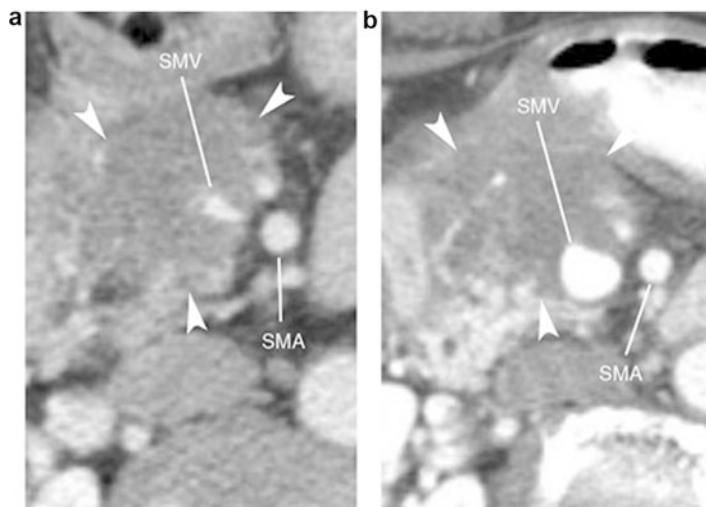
Pre- and posttreatment CT scans of a 70-year-old patient presenting with segmental venous near occlusion. (a) Pretreatment scan shows a hypodense mass (*white arrowheads*) involving the head of the pancreas with marked narrowing of the SMV. Patient's baseline CA19-9 was 71 U/ml. Patient was treated with gemcitabine and cisplatin every 2 weeks for 4 infusions followed by capecitabine-based chemoradiation (50.4 Gy); (b) after chemotherapy and chemoradiation, there was significant improvement in the caliber of the SMV without much change in the tumor size and the CA19-9 was 27 U/ml. At surgery, tumor was found extending substantially to the left of the SMA for a distance of more than a centimeter. This process extended to the right to entirely encase the tributaries to the SMV such that there would be no access to a reasonable trunk of the SMV to enable venous resection. Patient is currently 24 months out from her attempted surgery and undergoing chemotherapy for progressive disease manifested by carcinomatosis
